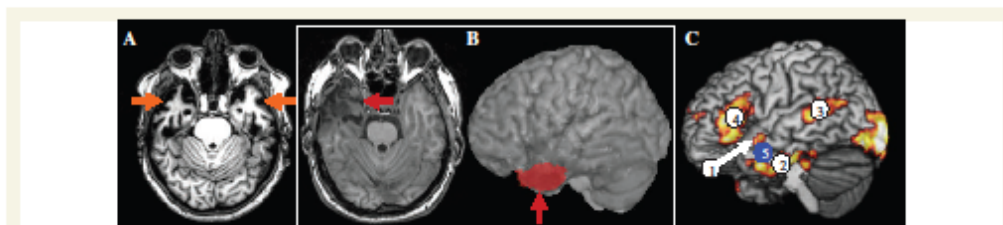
The puzzle of semantic memory in resection for TLE. (A) An example axial MRI for a patient with semantic dementia, with clear bilateral anterior temporal lobe atrophy (orange arrows) underpinning the patient's demonstrable semantic impairment. (B) A comparable axial slice from a patient following anterior temporal lobe unilateral resection for TLE (red arrow). The red region on the lateral view shows the resected area. This overlaps with the anterior temporal lobe regions (1 and 2 in C) activated by normal subjects in our functional MRI semantic studies (Binney et al., 2010) and also with the region (5) that we have stimulated with repetitive transcranial magnetic stimulation in normal participants to produce a selective semantic effect (Pobric et al., 2007; 2010; Lambon Ralph et al., 2009).
